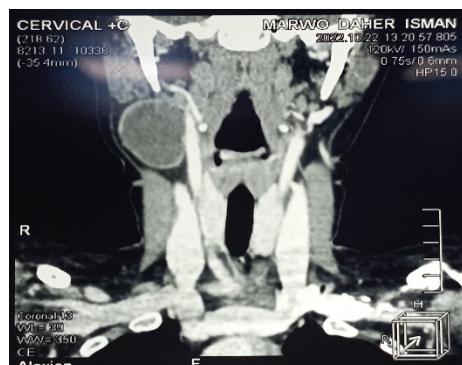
Cervical CT in coronal section: well-defined cystic formation in close contact with the vascular structures of the neck.
